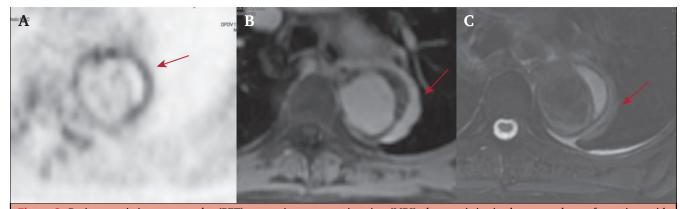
Positron emission tomography (PET) magnetic resonance imaging (MRI) characteristics in the acute phase of a patient with DeBakey type IIIA aortic dissection who suffered aortic dilatation and was operated on with a branched endograft 28 months after the index event. (A) PET inverted grey scale reveals increased fluorodeoxyglucose uptake in the aortic wall (arrow). (B) T1 weighted MRI showing wall thickening and gadolinium enhancement six minutes after injection. (C) T2 weighted MRI showing increased signal indicative of oedema.
